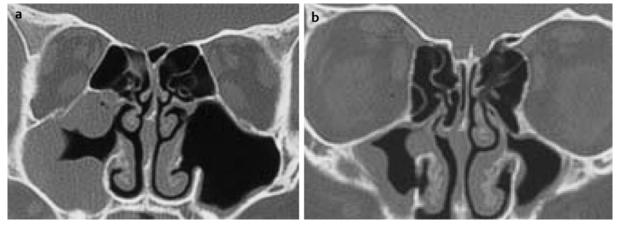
CT-scan (coronal plane) of a patient having been subjected to middle meatal antrostomy. "Missed ostium sequence" on the right side leading to persistence of maxillary sinusitis.
